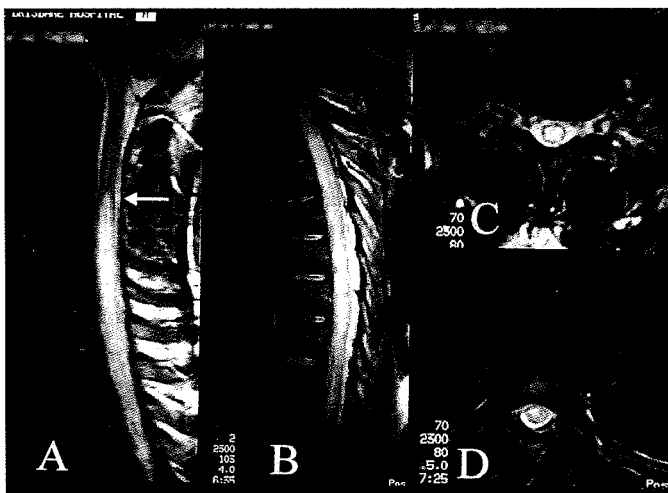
Initial magnetic resonance imaging of the spine and spinal cord. Sagittal T2 weighted spin echo midline images of the cervical (A) and thoracic cord (B) demonstrate diffuse oedema producing swelling of the cord from the conus to C4 level (arrow). Axial T2 weighted gradient echo images of the cervical (C) and thoracic cord (D) show the extensive cord involvement.
